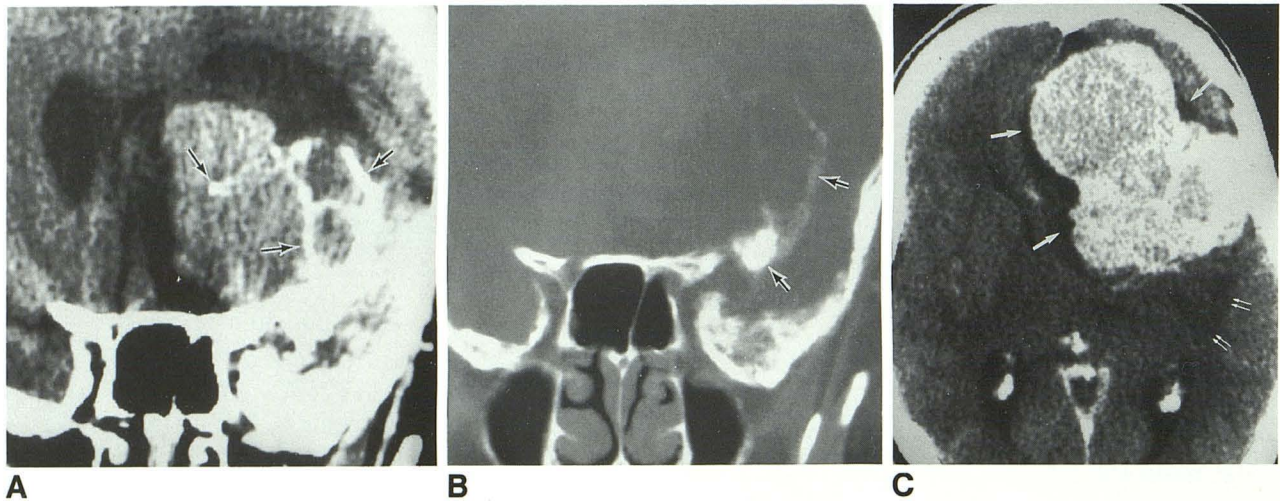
A, Coronal head CT scan without contrast shows a hyperdense globular mass with focal calcifications (*outlined arrows*) arising from a thickened sphenoid wing.
